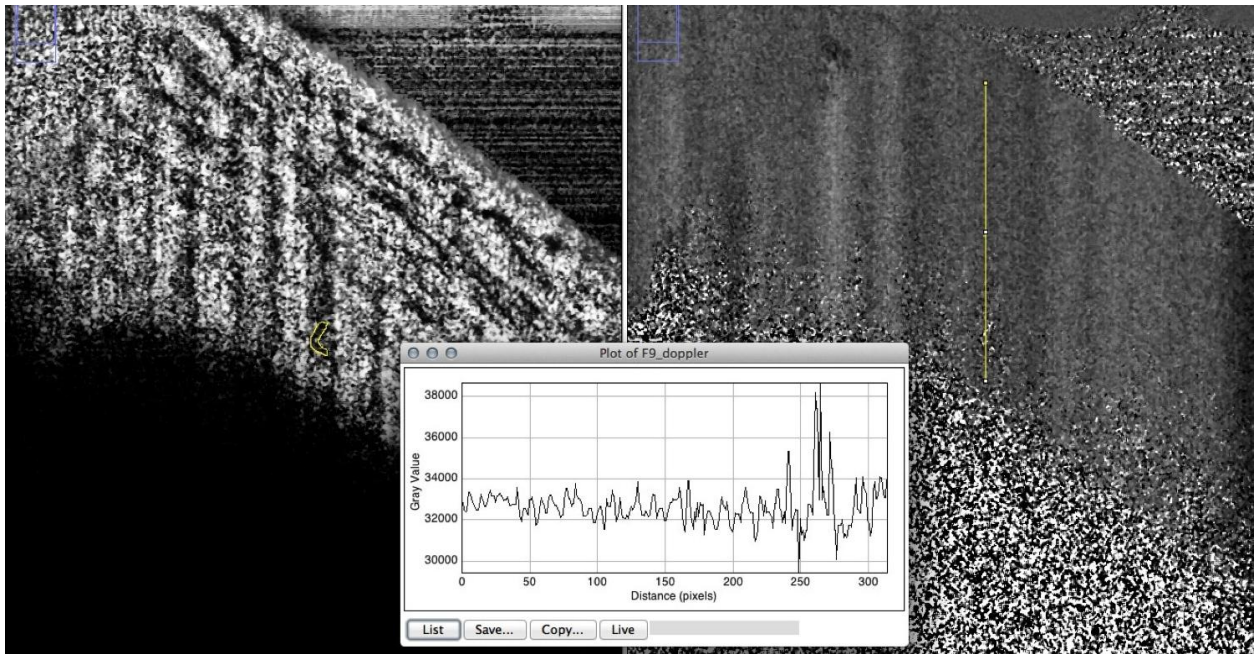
The Doppler signal within the small vessel is minimal but detectable and larger than background scatter.
